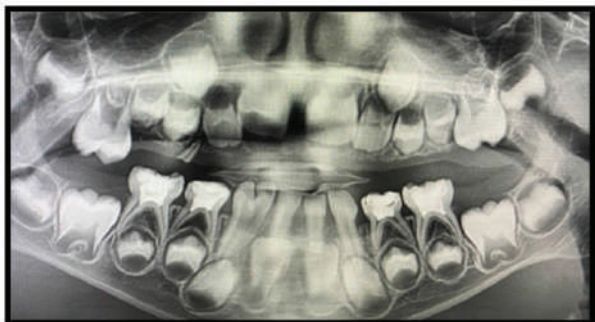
Fusion of teeth 82 and 83 in the panoramic radiograph of a 4-year-old male patient.
